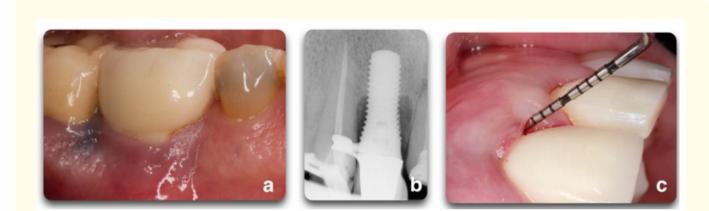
Shows peri-implant clinical parameters that, associated, can lead to a diagnosis of peri-implantitis. A. BOP/Suppuration, B. radiographic bone level \geq 3 mm, and C. in combination with PD \geq 6 mm [8].
